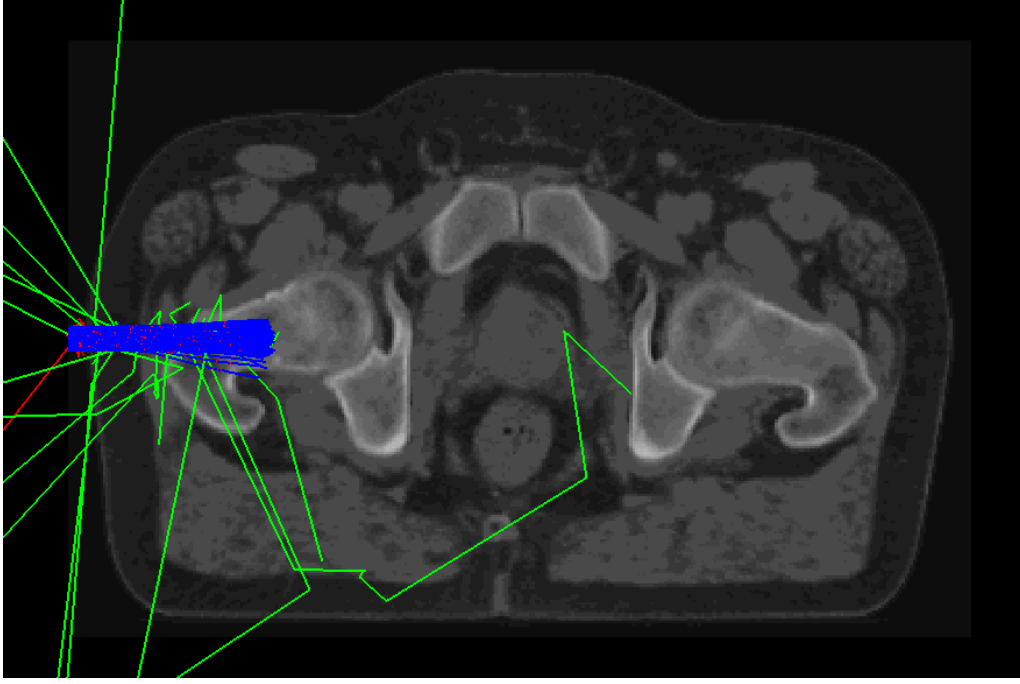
Visualization of the beam start position in TOPAS. In this example, a prostate patient CT dataset is irradiated with protons ($E = 100$ MeV, $N = 10^3$). Primary particles, i.e. protons are marked (blue lines), as well as secondary particles, i.e. electrons (red lines) and gamma rays (green lines).
